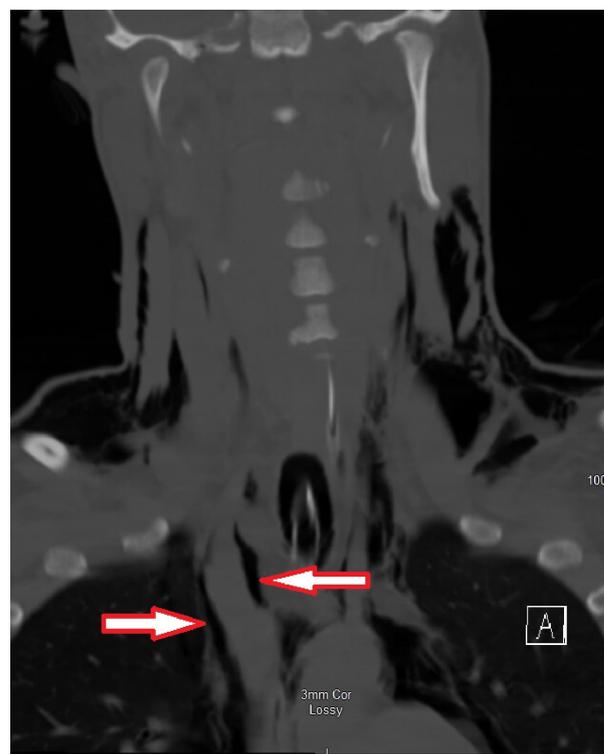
Computed tomography scan of the neck. Coronal section showing air (arrows) around the right internal jugular and brachiocephalic veins.
